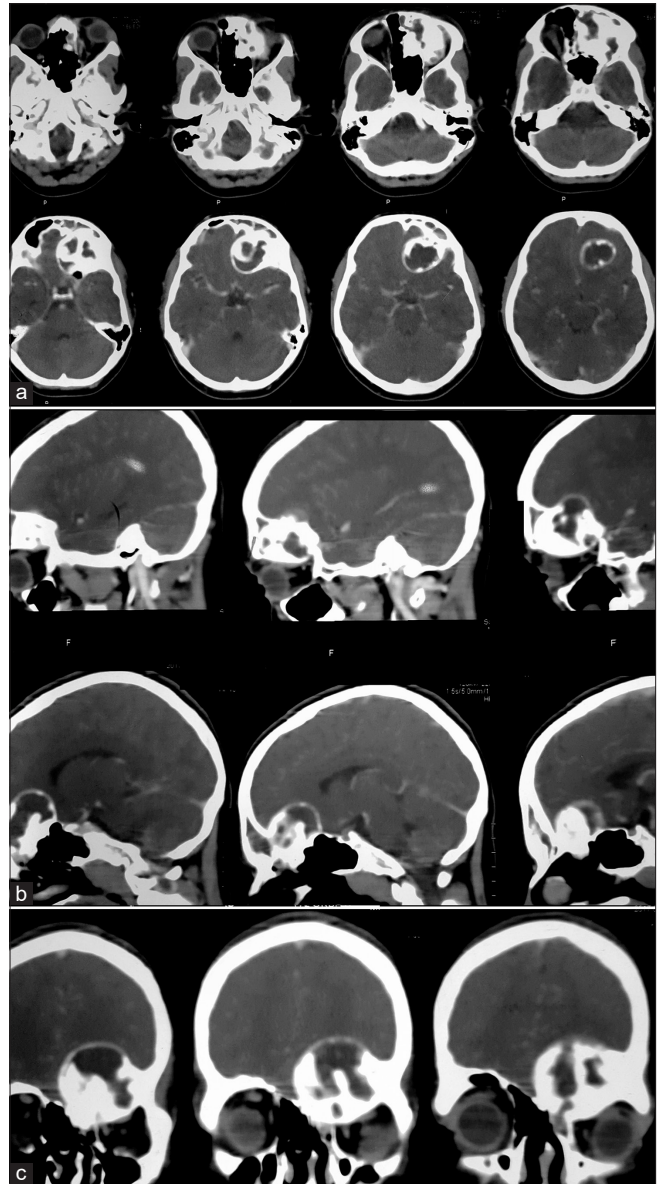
(a) Pre-operative CT brain with contrast axial sections demonstrating an anterior cranial fossa space occupying lesion with involvement of the orbital roof. There was a sclerotic contrast enhancing rim as well. (b) Preoperative CT brain with contrast sagittal sections demonstrating the lesion to be involving the orbital roof and causing mass effect and forward pushing the contents of the orbit. (c) Preoperative CT brain with contrast coronal sections through the orbit demonstrating the extent of the lesion to the midline and possible involvement of the cribriform plate.
